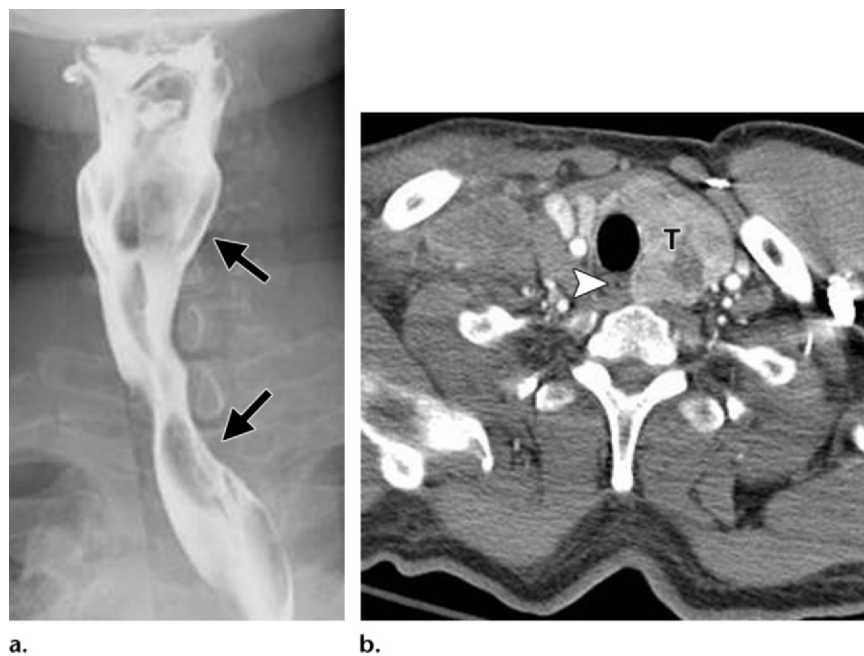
Mass effect due to thyroid disease. (a) Anteroposterior image obtained during swallowing shows extrinsic mass effect (arrows) from a large mass in the left side of the neck, which displaces the cervical esophagus to the right. A transient right lateral pharyngeal pouch is also noted. (b) Contrast-enhanced CT image shows a large left thyroid goiter (T) displacing the trachea and esophagus (arrowhead) to the right of midline.
